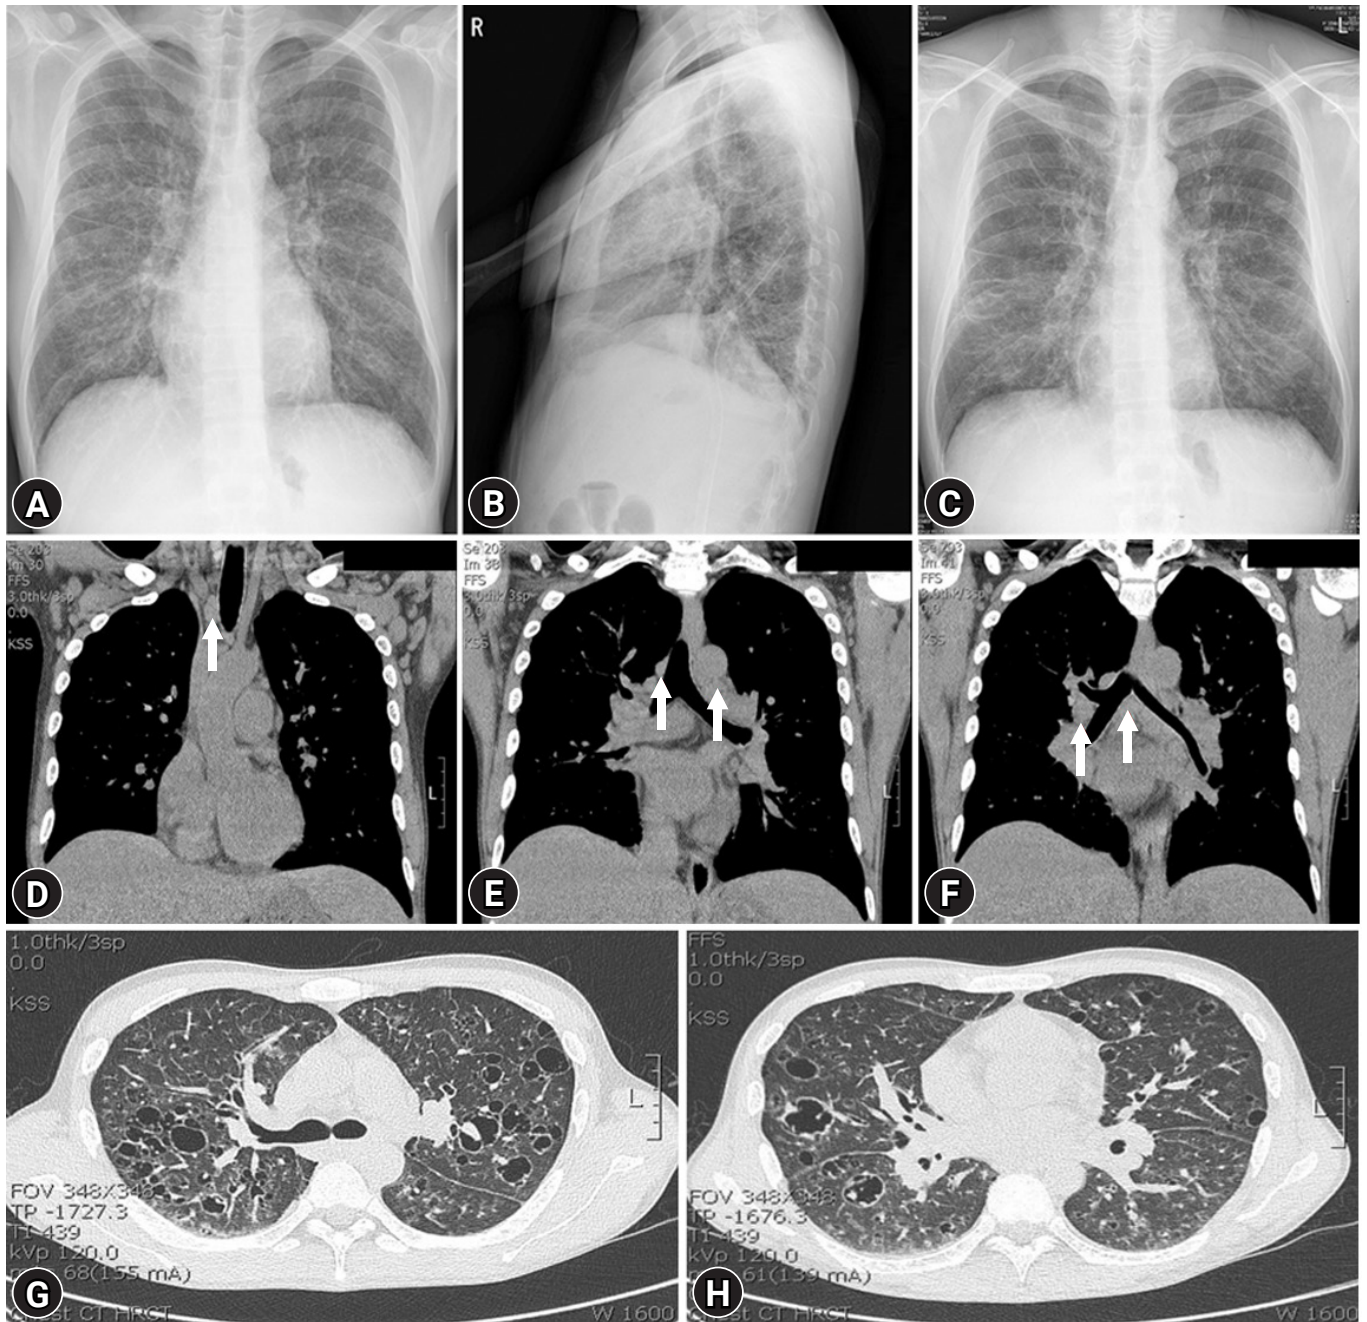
(A–C) Fibrostriky opacity and dense infiltrations are seen on both lower lung fields in initial chest X-rays (A, B) and a follow-up chest anteroposterior X-ray (C). (D, E) Coronal chest computed tomography (CT) images reveal multiple enlarged lymph nodes in both upper (D) and lower paratracheal, subaortic (E), hilar, and subcarinal areas (F) (arrows). (G, H) Axial chest CT images show multifocal ground-glass opacity with multiple variable-sized cystic lesions in both lower lung fields.
